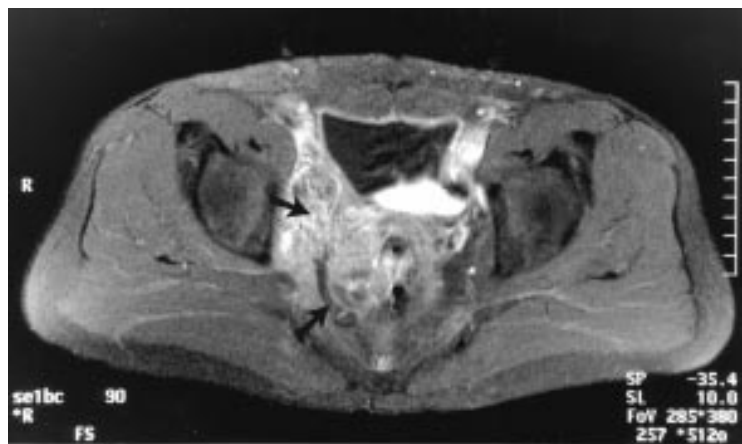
Magnetic resonance image showing extrinsic compression of the ileal pouch (arrows) with distention of the proximal bowel.
